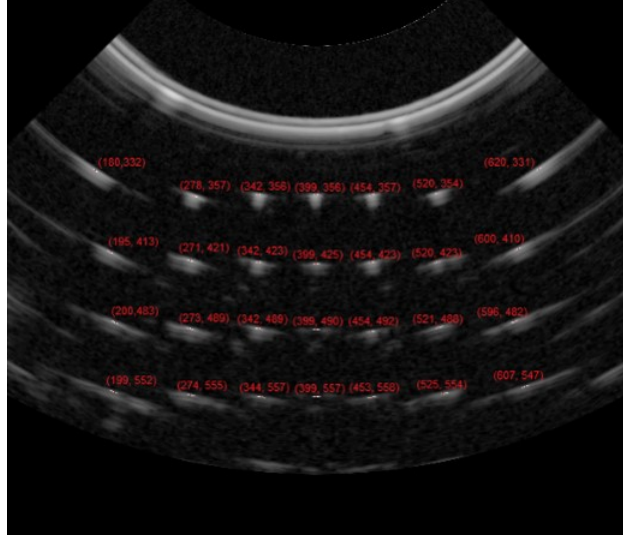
Ultrasound image during calibration of intrinsic parameters.
